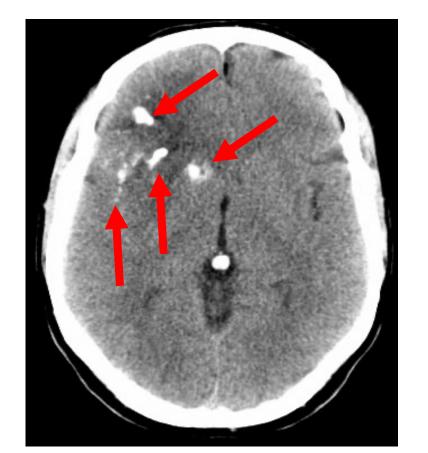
Non-contrast CT shows an oligodendroglioma with typical calcifications (arrows).
